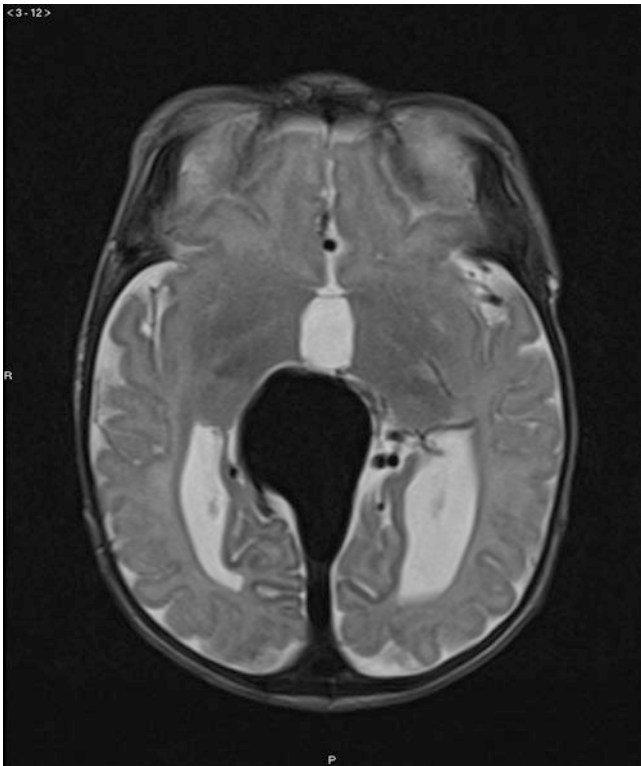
VGAM. Axial T2-weighted MR image demonstrates a large, spherical, hypointense flow void posterior to the third ventricle, consistent with a VGAM. There is mild dilatation of the lateral and third ventricles
